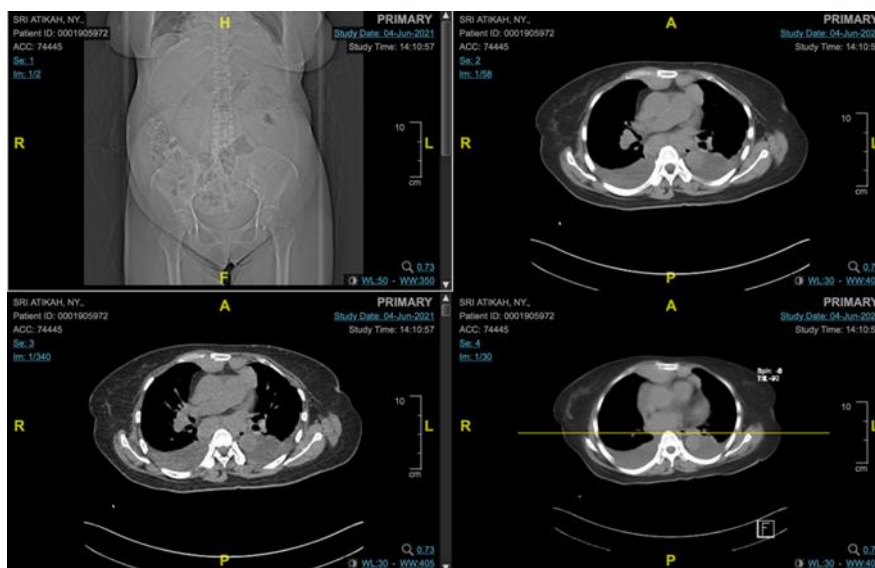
CT Scan abdomen
